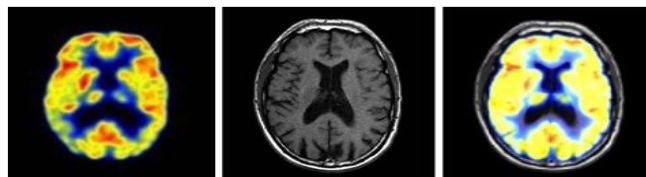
Input PET (left) fused with input MRI (middle) to give final fused output (right) in dataset 3
